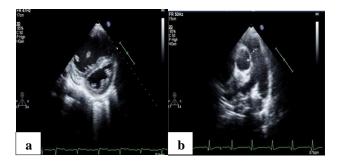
(a) Parasternal short axis view: D shaped septum, and (b) PSAX view: dilated MPA.
